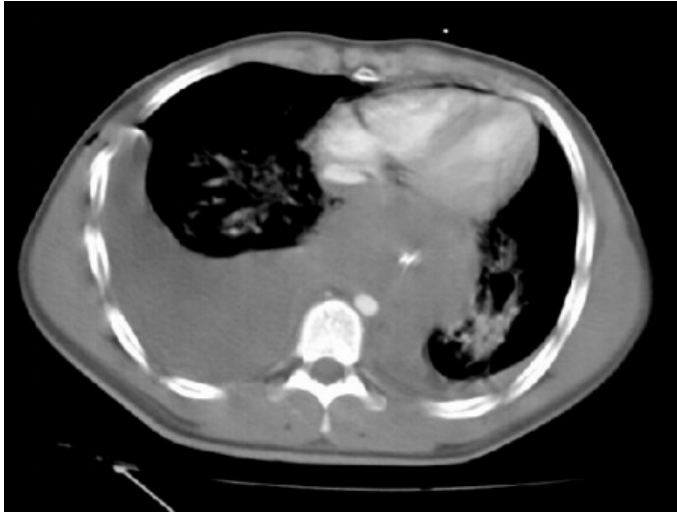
CT scan showing right haemothorax due to aortic rupture.
